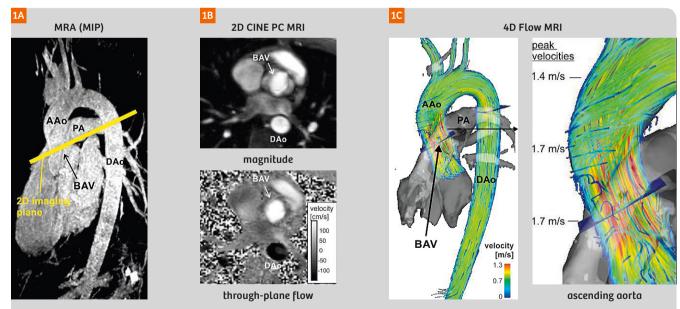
MR angiography (MRA, depicted as a maximum intensity projection, MIP) and 2D CINE PC-MRI in a patient with bicuspid aortic valve (BAV) disease. The patient underwent standard MR angiography (1A) as well as 2D CINE PC-MRI (1B) for the assessment of valve morphology and flow quantification at the level of the aortic valve in the ascending aorta (AAo). 1B shows the maximum aortic valve opening and blood flow during peak systole. The yellow line in 1A shows the imaging plane for 2D CINE PC-MRI acquisitions in 1B. (1C) 3D streamline visualization of systolic blood flow in the thoracic aorta as assessed by 4D Flow MRI. Note that 4D Flow MRI provides full volumetric coverage of the thoracic aorta and flexible retrospective quantification of peak systolic velocities at multiple locations in the thoracic aorta which revealed a peak velocity of 1.7 m/s distal to the BAV. DAo = descending aorta, PA = pulmonary artery
